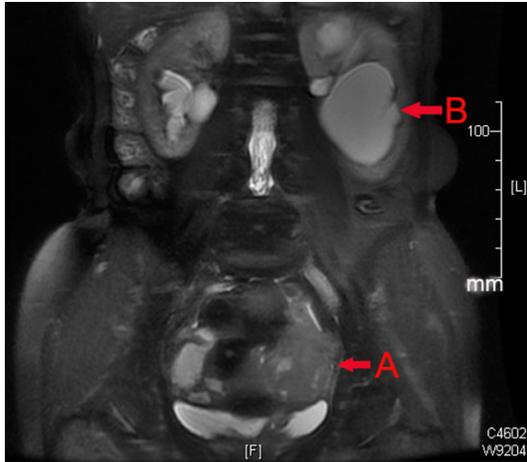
MRI scan revealing a mass measuring ~7 × 8 cm in the left pelvic cavity (A), with severe hydronephrosis (B). MRI, magnetic resonance imaging.
